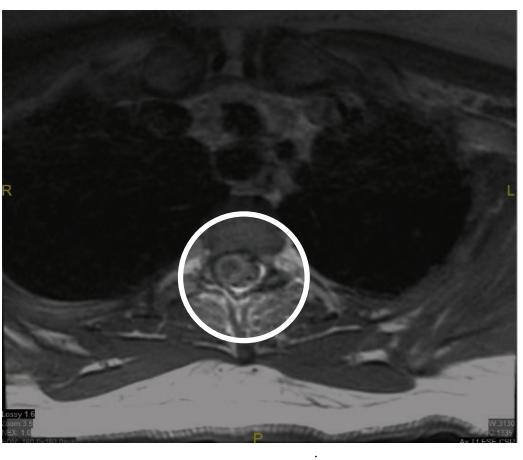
Thoracic MRI expressing cord edema and expansion, presumably reflecting venous congestion/ hypertension. The cord appears to be scalloped due to dilated perivascular vessels.
